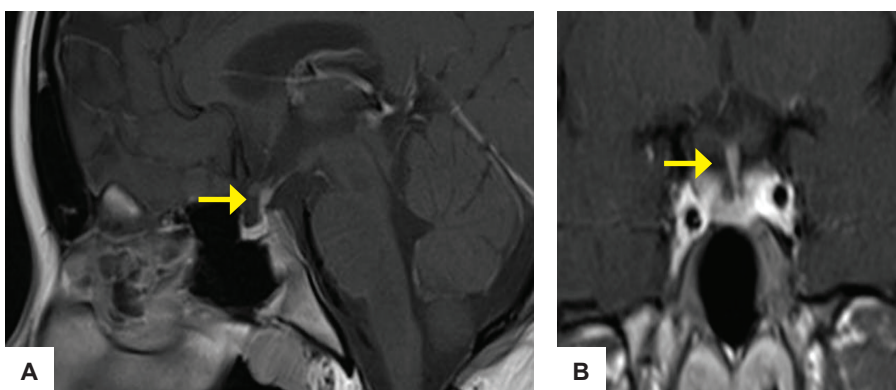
Pituitary MRI. T1 post-contrast in axial (A) and mid-sagittal (B) demonstrate homogeneous enhancement of the pituitary gland. On the mid-sagittal plane, at the optic chiasm level, a subtle enhancing pituitary stalk lesion, with focal thickening (yellow arrow) results in the loss of a normal tapering pituitary stalk.
